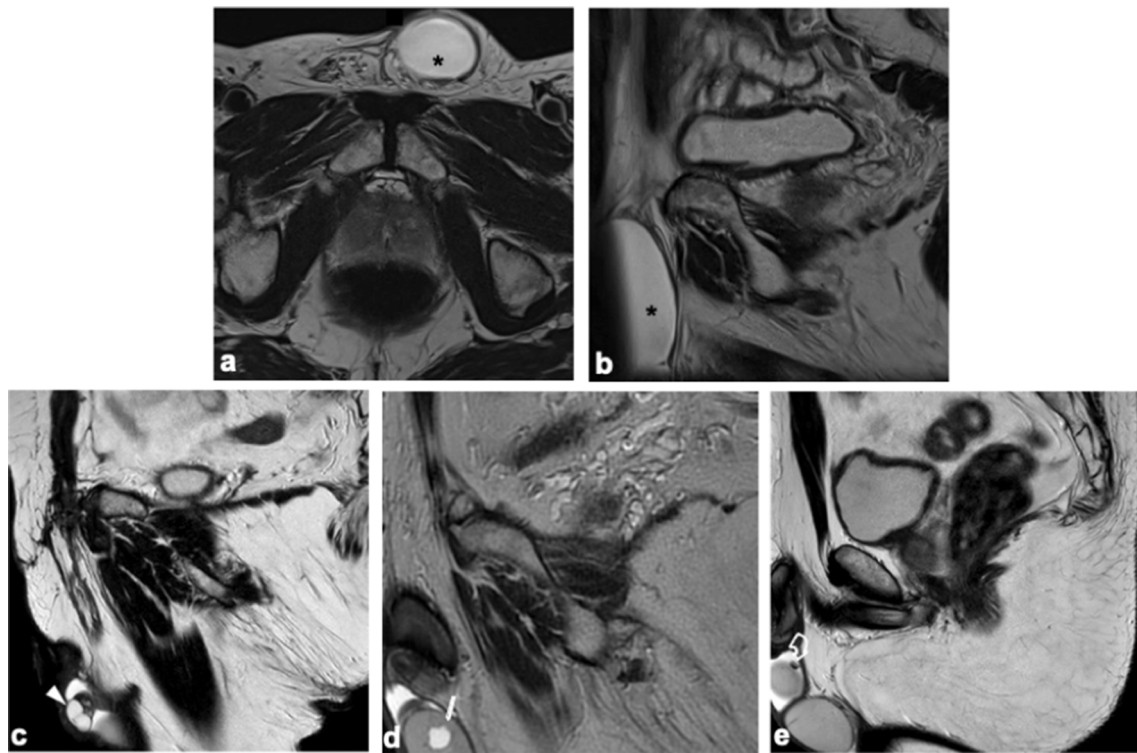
Axial (a) and sagittal (b) T2w images show a fluid collection (asterisks) along the spermatic cord that lies superior to the testicle and does not communicate with the scrotal sac, in keeping with spermatic cord hydrocele. Sagittal T2w image (c) shows two small cysts of the epididymal head (arrowhead). Sagittal T2w image (d) shows a small rounded simple testicular cyst (arrow). Sagittal T2w image (e) shows left hydrocele containing a small low signal rounded lesion (curved arrow), consistent with scrotolith. T2w T2-weighted.
